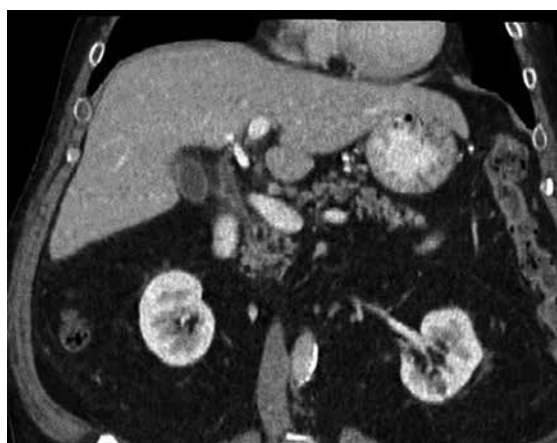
Complete resolution of the hepatic abscess. CT of the abdomen revealing complete resolution of the hepatic abscess.
